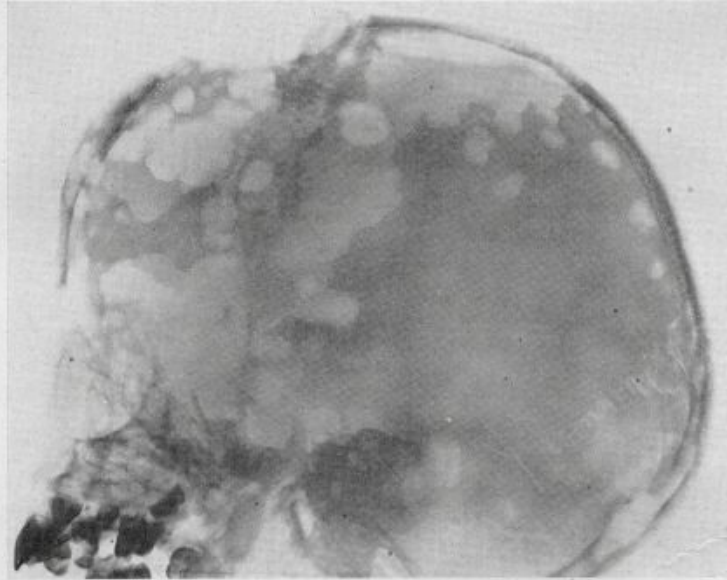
x-Ray of skull showing bone defects: lateral view.
